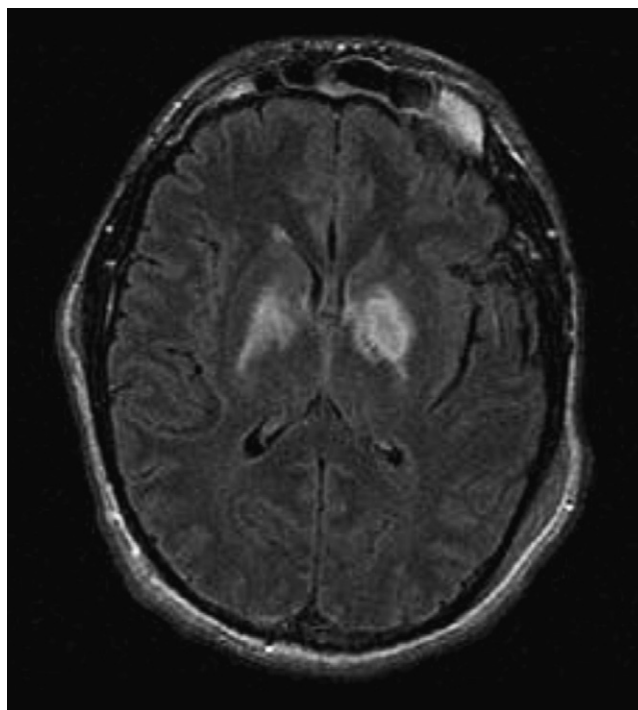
Magnetic resonance imaging of patient demonstrating bilateral basal ganglia infarction.
